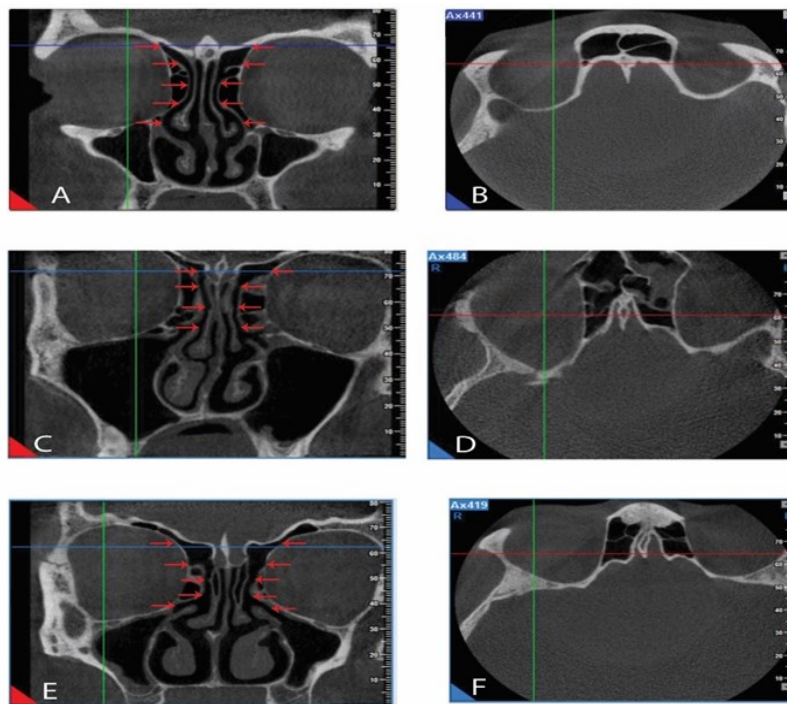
The coronal section of CBCT images (A-C-E), indicating the frontal recess position (red arrows) relative to the position of CG in the axial section at the anterior, middle and posterior one-third of CG (red lines) (F-B-D)
